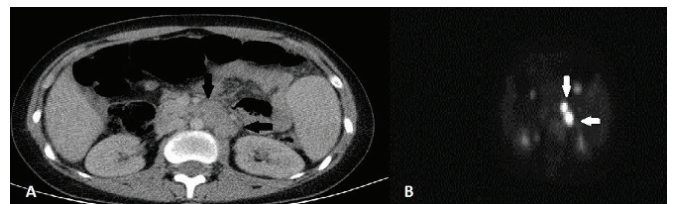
Paraaortic enlarged lymph nodes are seen (arrows). A) Axial computed tomography imaging. B) Axial fluoro-18 fluorodeoxyglucose-positron emission tomography imaging
